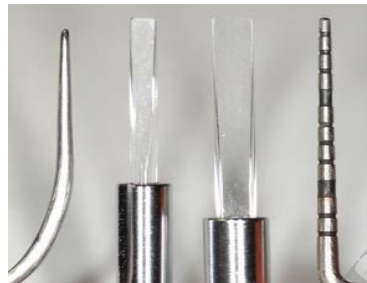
Working tips of ultrasonic scaler (left) Er:YAG laser device (centre) with dimensions comparable to those of periodontal probe (right).
